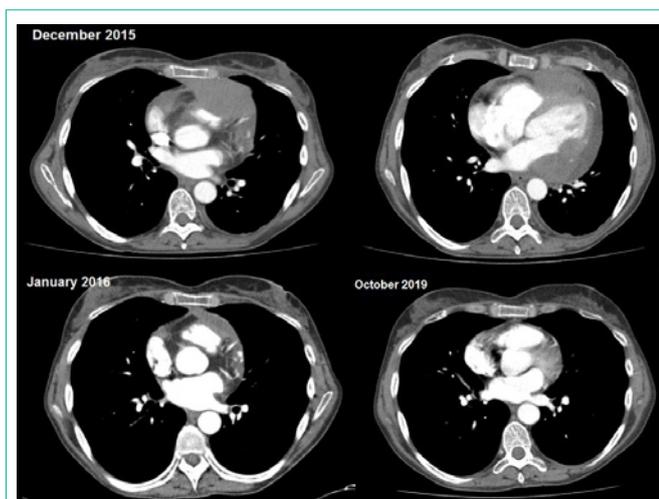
Sorafenib was started (in December 2015) at dose of 400 mgr/12 h. After first month of treatment, pericardial lesions decreased from 5 to 1.7 cm in diameter. Subsequent CT scans showed progressive decrease of lesions until resolution in July 2016. In last CTs pericardial thickening is almost non-existent, without new lesions.
